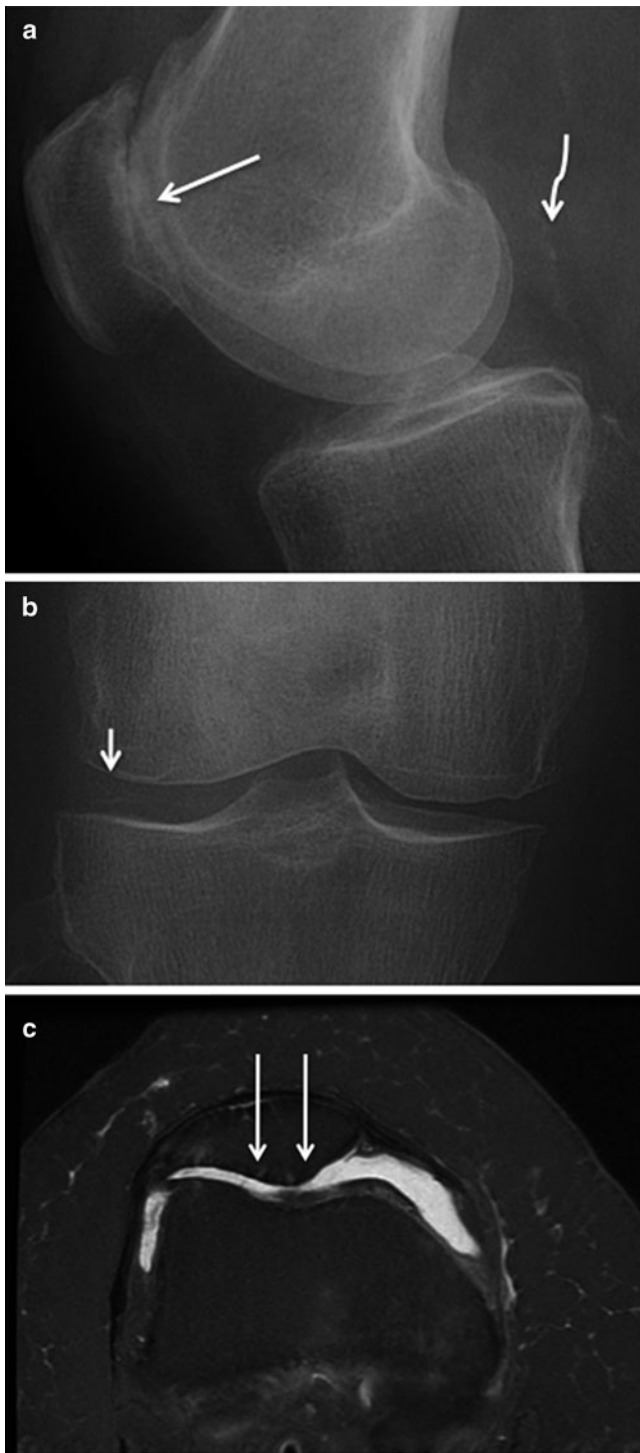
(a–c). Anteroposterior (a) and lateral (b) radiographs as well as axial fat-saturated intermediate-weighted (fs iw) FSE sequence (c) in a patient with calcium pyrophosphate deposition disease (CPPD), which typically affects the femoro-patellar joint and can be associated with severe cartilage loss (*large arrows* in a and c). In addition meniscal calcifications (*small arrow* in b) and calcifications in the gastrocnemius muscles (*curved arrow* in a) are shown
